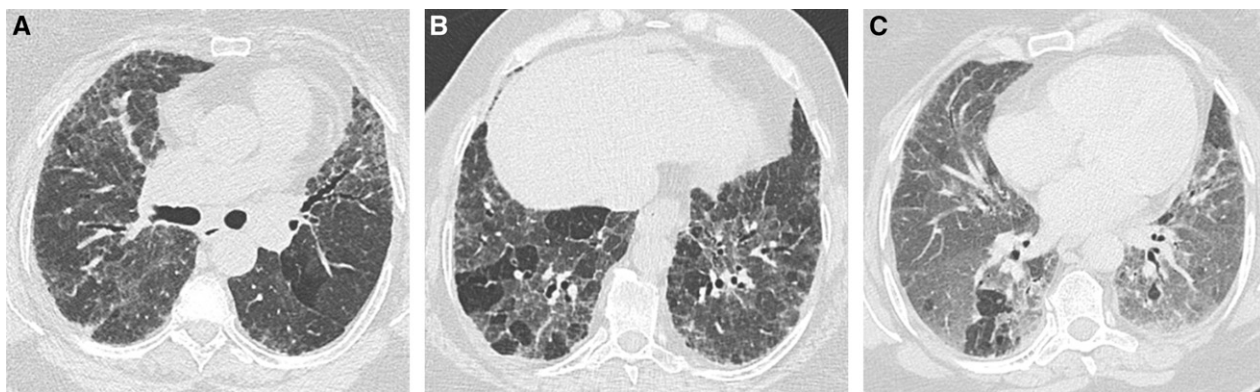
Computed tomography (CT) pattern suggestive of an alternative diagnosis for lung fibrosis. (A and B) Transverse CT sections obtained at deep inspiration showing disseminated lung infiltration, sparing some secondary pulmonary lobules in lung bases. (C) Transverse CT section obtained at expiration confirming lobular air trapping, all findings being highly suggestive of chronic hypersensitivity pneumonitis.
